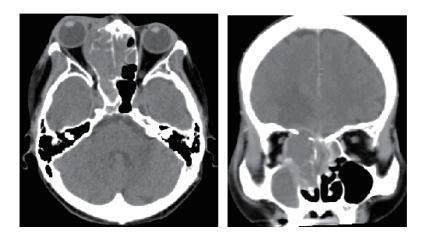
Coronal and axial computed tomography shows a soft-tissue-density mass in the right frontal, maxillary, sphenoid, and ethmoid sinuses and the right nasal cavity. The orbital medial wall, nasal septum, and frontal skull base have been destroyed by the tumor.
